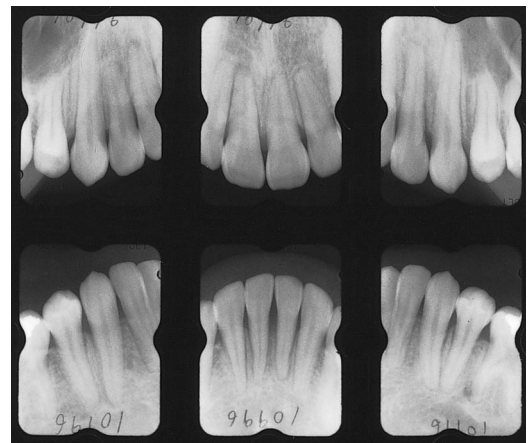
Periapical radiographs (post-treatment).
